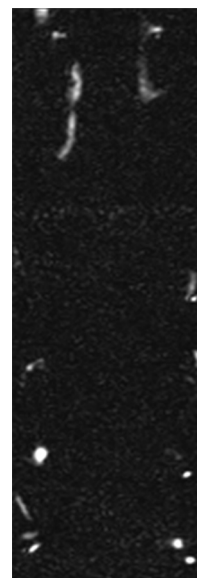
Epidural fluid collection from the second cervical vertebra (C₂) to the third lumbar vertebra (L₃) (a and b: white arrows) and myelomalacia of the spinal cord from C₂ to the second thoracic vertebra (T₂) (a: white arrowheads) on the sagittal T₂-weighted image. Hemosiderin deposition along the cerebellar folia on the T₂*-weighted image (c: white dotted arrow). CT myelogram demonstrated cerebrospinal fluid (CSF) leakage into epidural fluid collection (d: black arrows), but the location of the dural defect was not identified. Sagittal phase contrast MRI (PC-MRI), on which the flow direction was feet-head, indicated CSF flow through the dural defect at T₁₋₂ (e: black dotted arrow). The acquisition plane of oblique coronal PC-MRI was selected to contain the CSF flow (f: white line). An oblique coronal phase contrast MRI (PC-MRI) series (g-i) clearly demonstrated anteroposterior dot-like flow at the dural defect (i: white curved arrow). The peak CSF flow velocity was 11.74 cm/s. Axial balanced fast field echo imaging revealed the dural defect (j: black arrowhead) between the epidural fluid collection (j: white arrow) and intradural CSF. The dural defect was surgically confirmed (k: black arrowhead).
